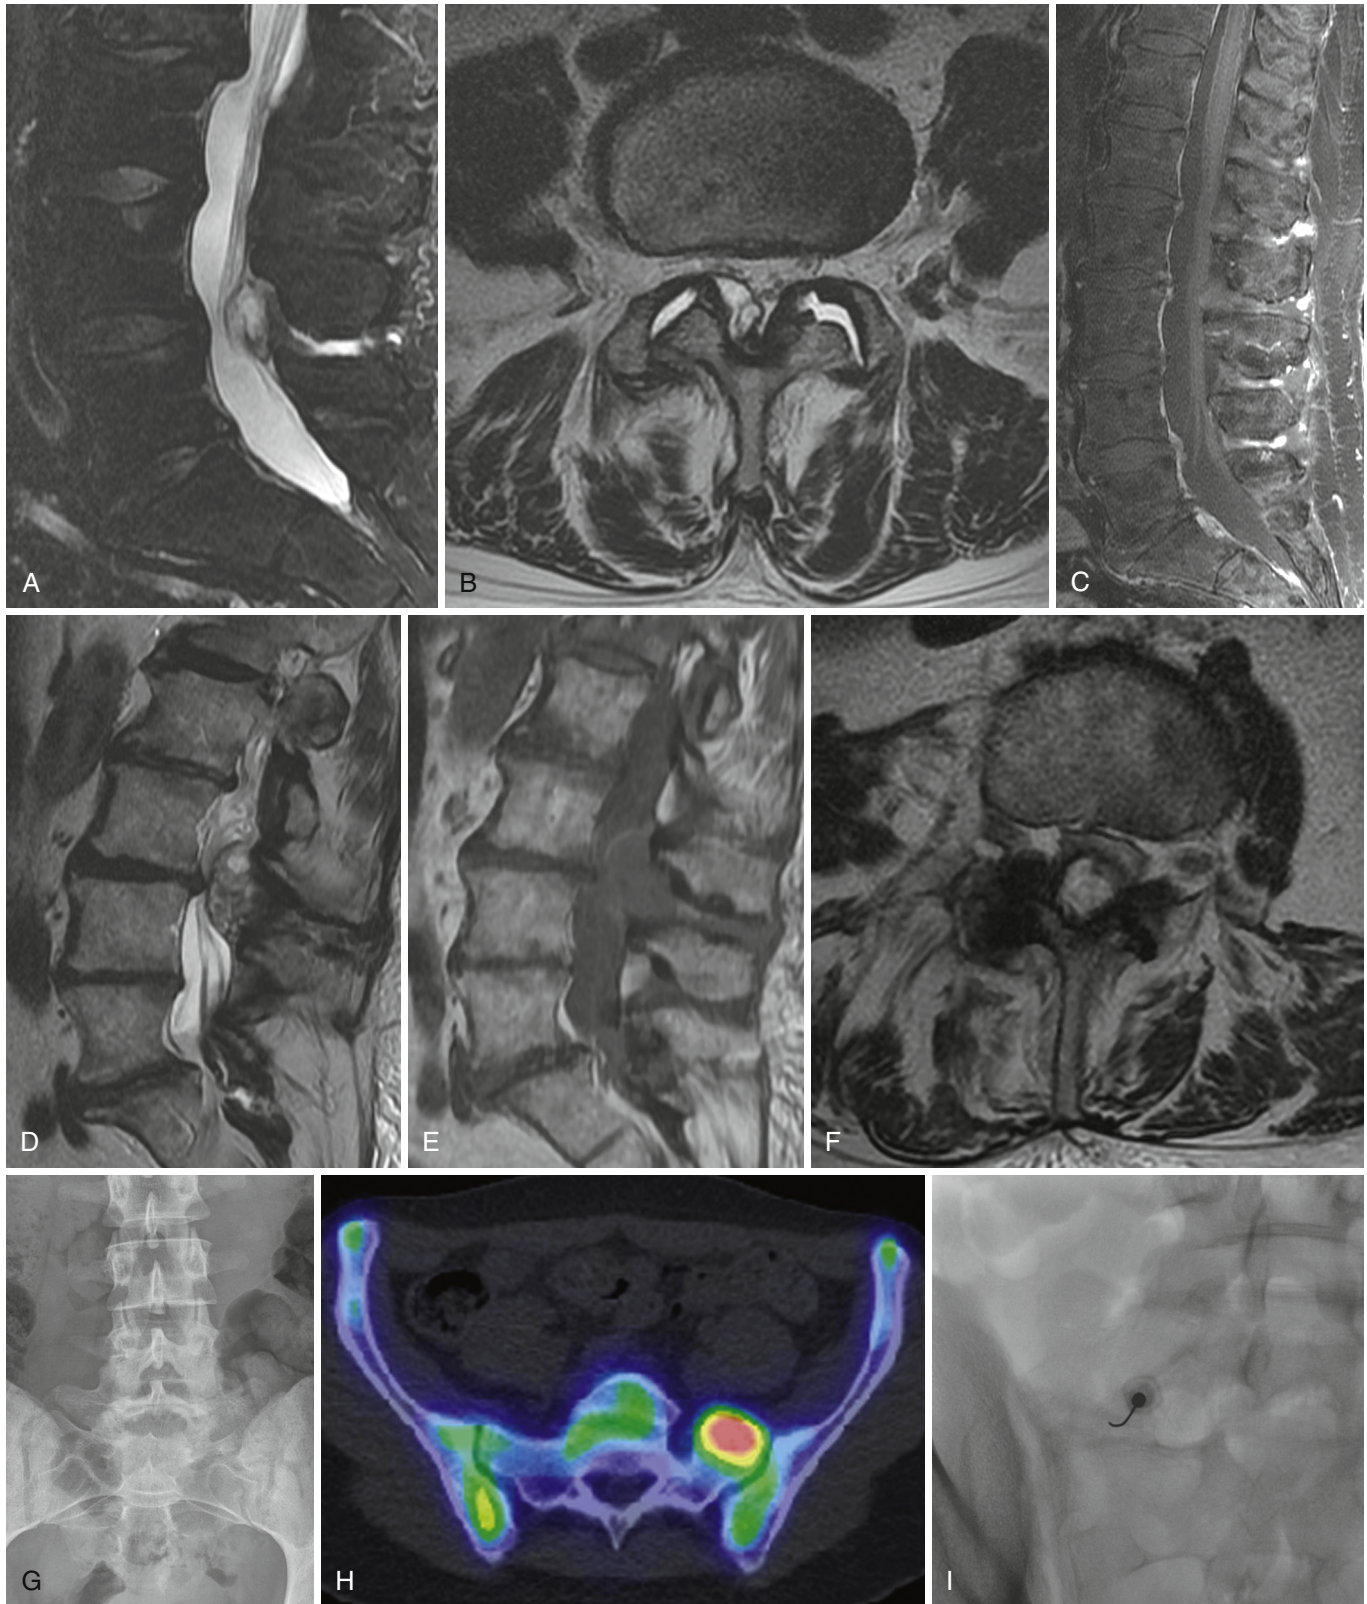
Baastrup's disease and Bertolotti's syndrome as posterior element pain generators. An elderly male presents with neurogenic intermittent claudication. T2 fat-saturated sagittal image (A) and axial T2 image at the L4-5 interspace (B) demonstrate that the compressive lesion is a right paramedian dorsal cyst in continuity with the interspinous pseudobursae of Baastrup's disease. There are also facet joint effusions. In another patient with axial pain (C), a fat-saturated, enhanced T1-weighted image shows inflammatory enhancement in the interspinous ligaments of T12-L4. Sagittal T2 (D) and T1 (E) images of another patient demonstrate a large complex midline dorsal cyst emerging from an interspinous pseudobursae at the L3-4 interspace (axial T2 image [F]). A 17-year-old female (frontal lumbar spine radiograph [G]) presented with intractable left lumbosacral junction region pain. Note left pseudoarthrosis (Bertolotti's syndrome). SPECT/CT image (H) shows markedly increased uptake at the pseudoarthrosis; pain was relieved with injection into this site (fluoro image [I]; note that the patient is prone).
